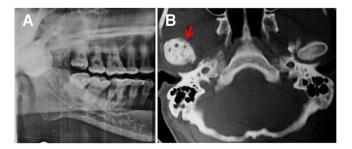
Orthopantomogram showing radiopaque lesion involving right condyle (A); CT revealing the hyperdense lesion replacing the condylar head (arrow head) (B).
